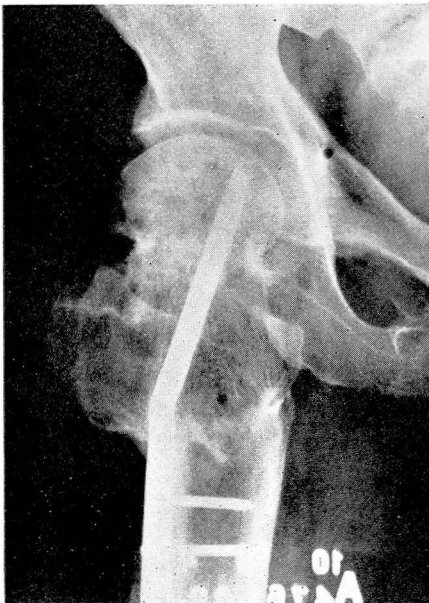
Anteroposterior roentgenogram eighteen months after operation in case shown in fig. 24, showing union and revascularization of the head.
